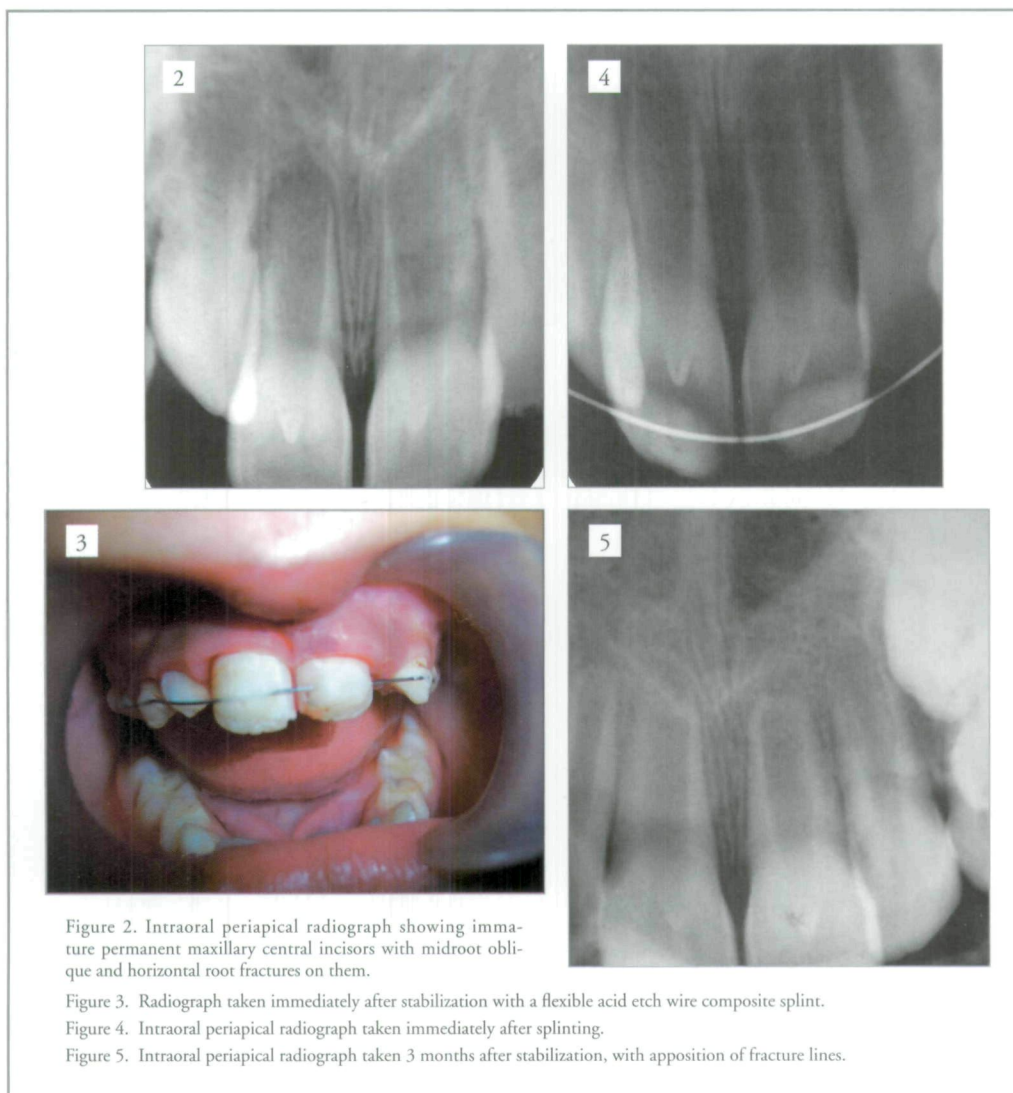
Intraoral periapical radiograph showing immature permanent maxillary central incisors with midroot oblique and horizontal root fractures on them.
